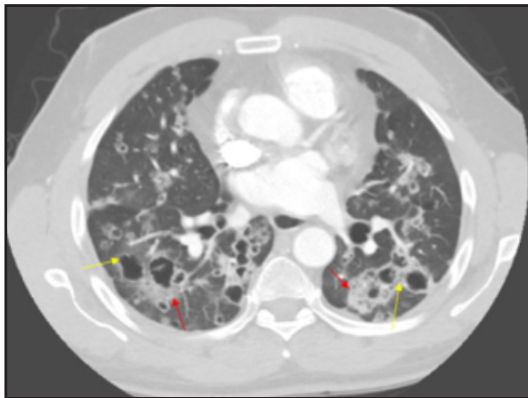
Metastatic colon cancer. Axial-enhanced CT image demonstrating multiple bilateral cavitary lesions (yellow arrows), which were biopsied and consistent with metastatic colon cancer. There is associated surrounding hemorrhage presenting as ground-glass density (red arrows).
